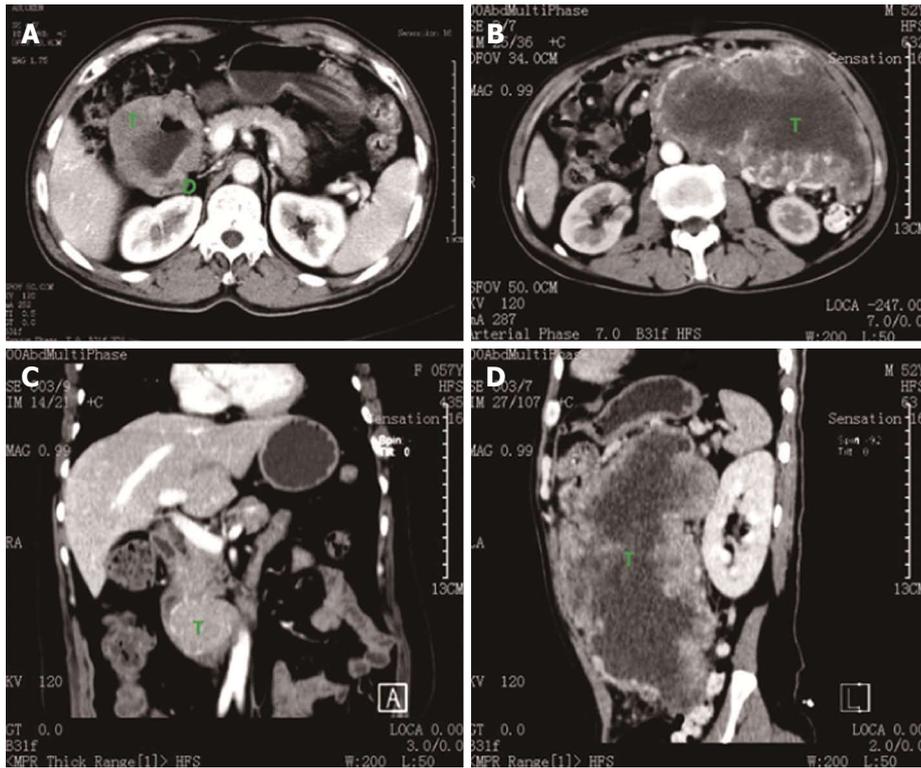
Respective computed tomography images. A: For case 28; B, D: For case 20; C: For case 18. (T: Tumor; D: Duodenum).
